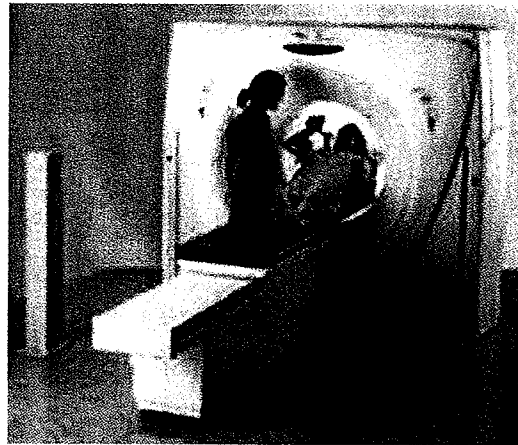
Large bore (85 cm physical aperture) oncology CT scanner showing breast patient positioning (photo reproduced by permission of Phillips Medical Systems).
